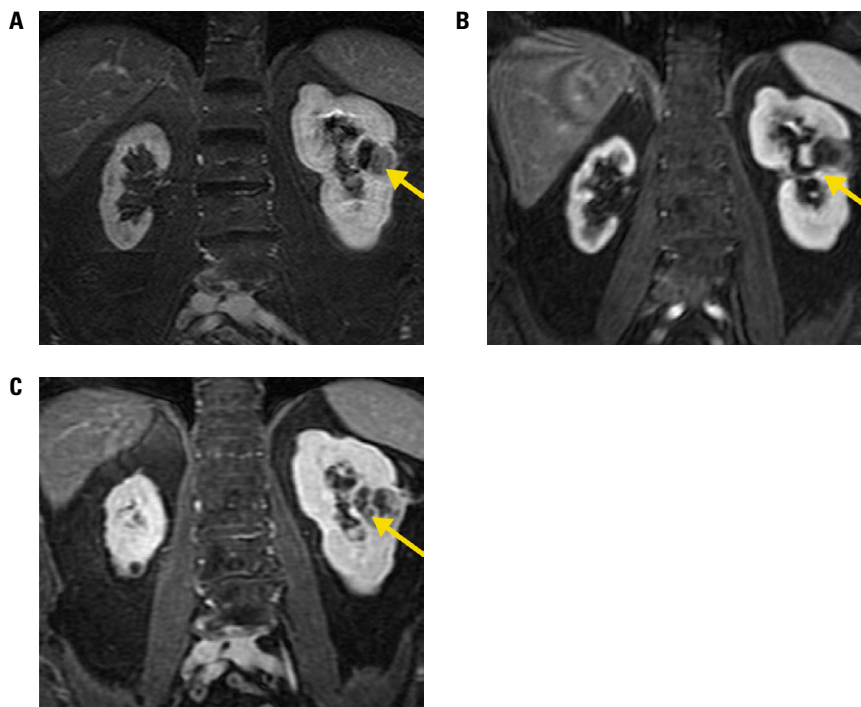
Identification of Tumour Recurrence on MRI
